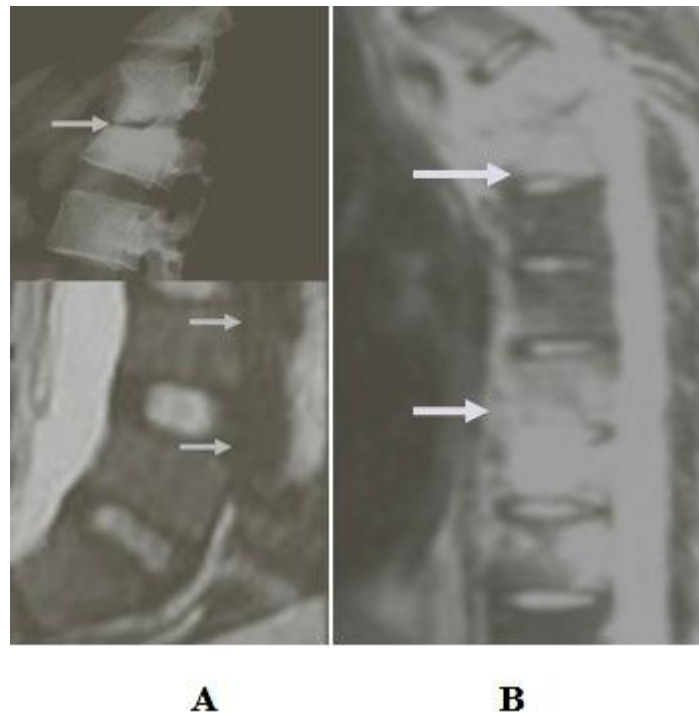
A, Plain X-rays discovered single thoracic lesion and MRI scan revealed early 2 lumbar lesions. B, MRI scan detected thoracic and lumbar lesions in kyphotic patient
